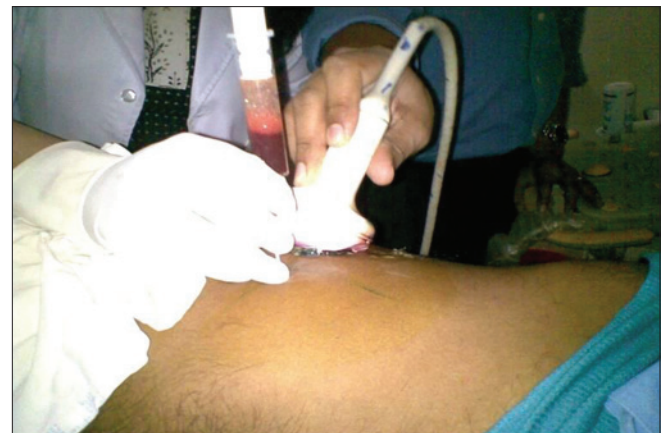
Ultrasound guided percutaneous aspiration of hematoma
